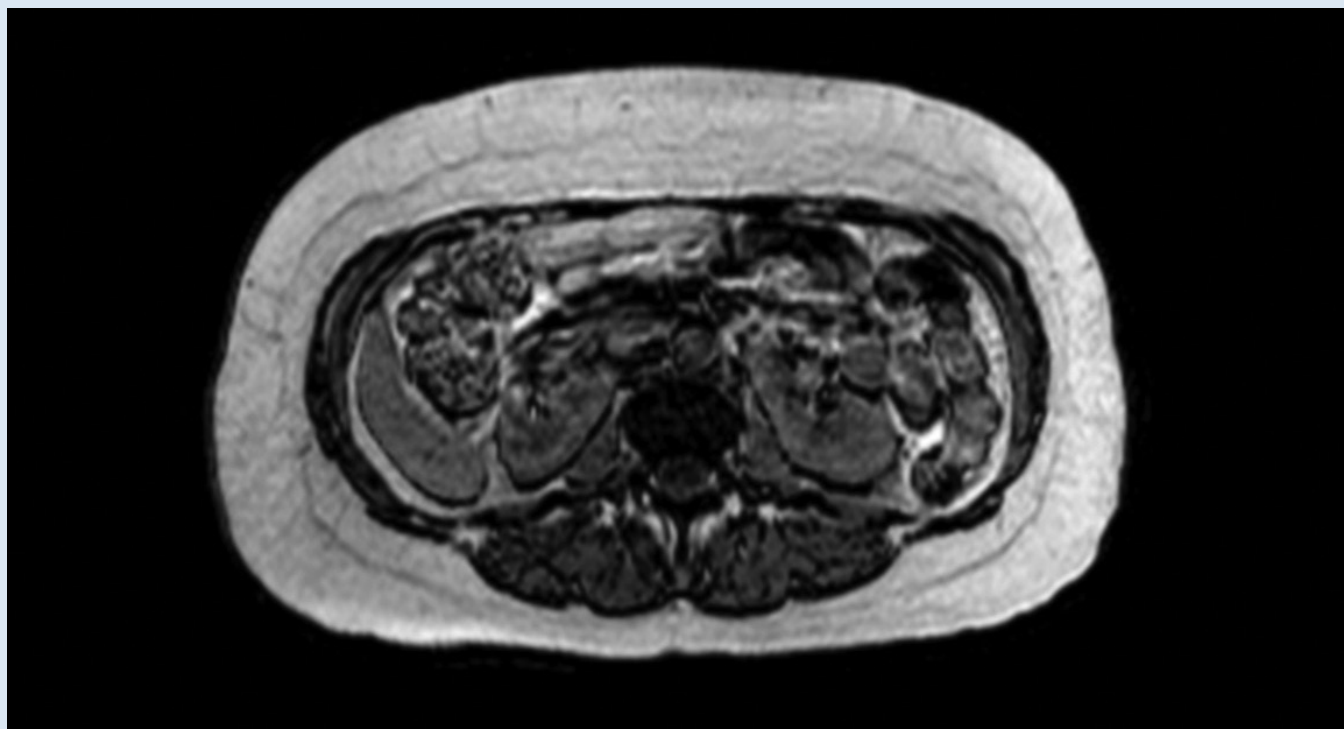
MRI of 2.3x2.7 centimeter rounded mass
